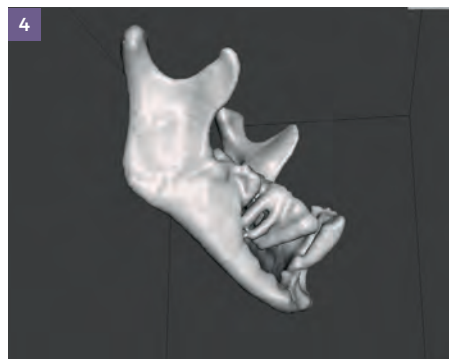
CT-derived anatomical data is processed using Invesalious to isolate skeletal structures and generate a digital mandible
